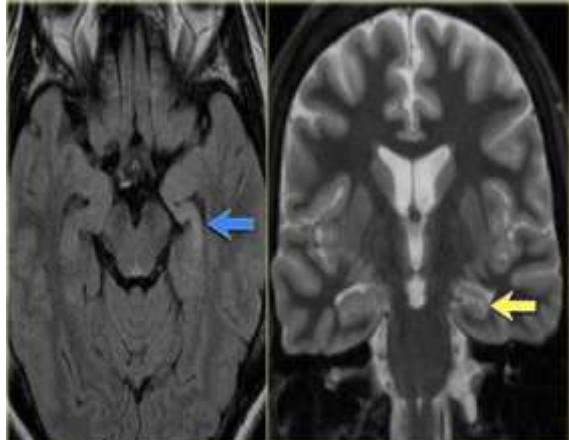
Left mesial temporal sclerosis showing hippocampal atrophy and T2/FLAIR hyperintensity
